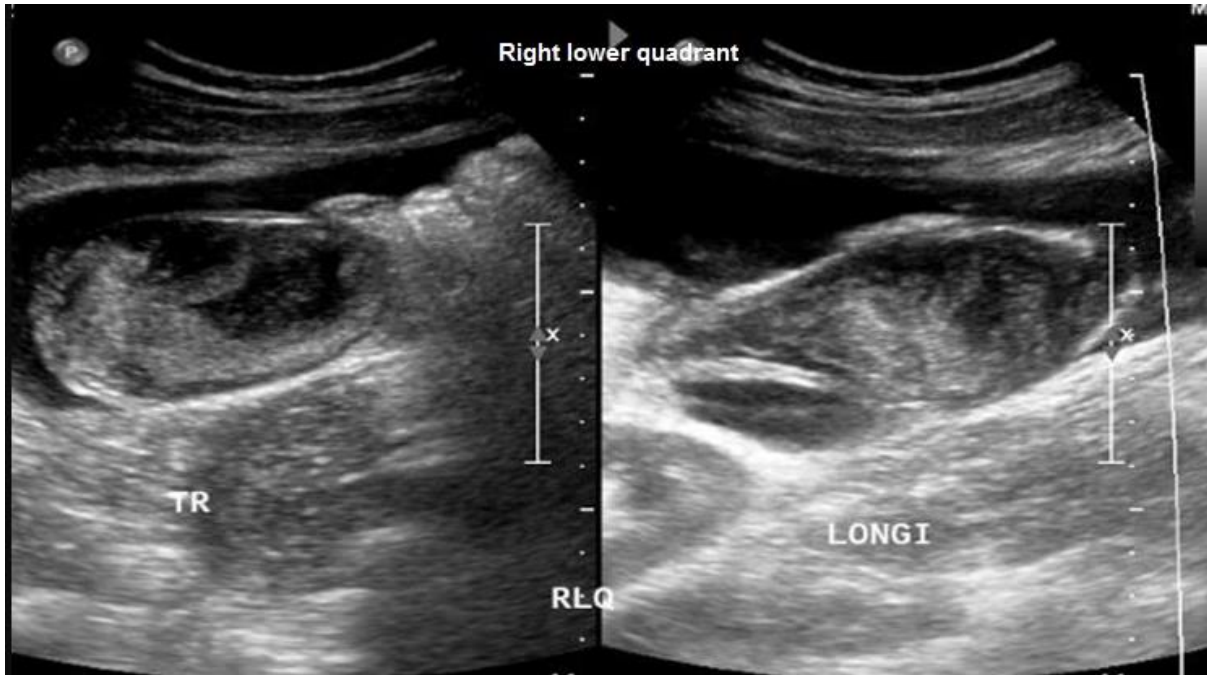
Axial and longitudinal Ultrasound Images, Right lower quadrant. Markedly dilated Appendix with echogenic internal debris and flimsy septation “wavy onion skin peel appearance” with peri-appendiceal collection.
